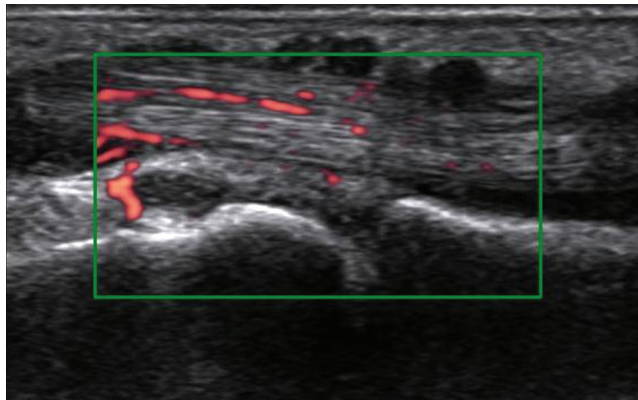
Grayscale ultrasonography (GSUS) and power Doppler ultrasonography (PDUS) of 3<sup>rd</sup> MCP joint dorsal side show grade 2 synovitis by GSUS and grade 3 synovitis by PDUS.
